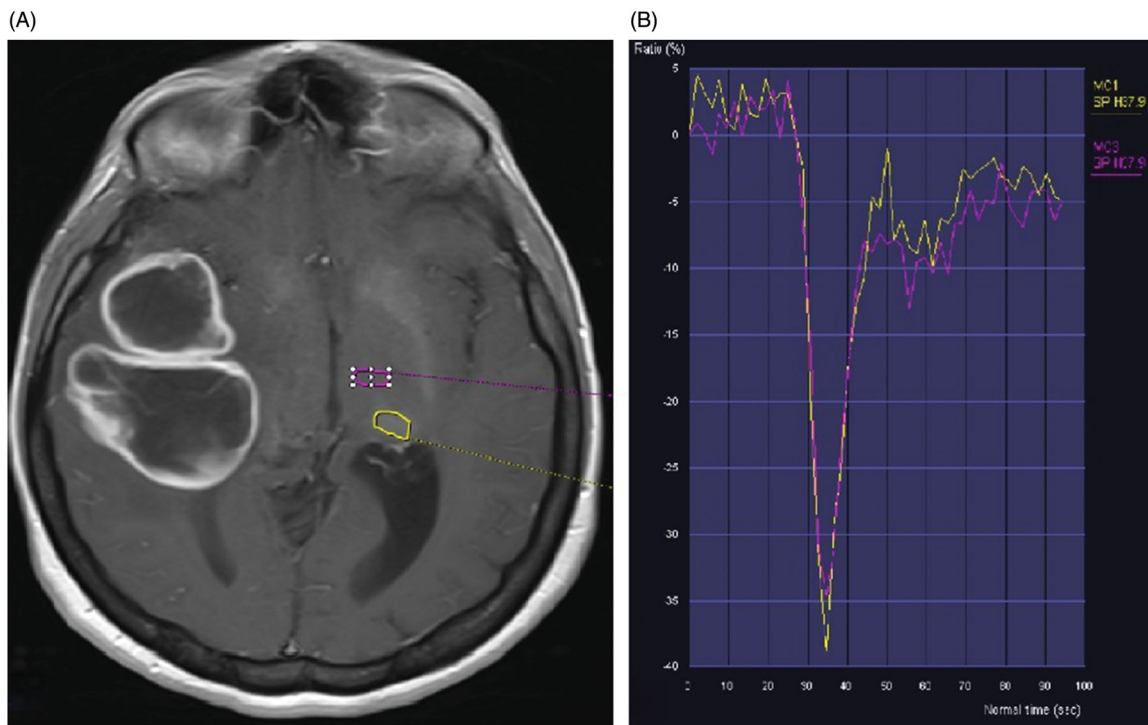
(A) Axial post-contrast T1-weighted imaging and (B) signal intensity time curves shows no perfusion difference between calcified (yellow) and noncalcified area (purple) in the thalamus.
